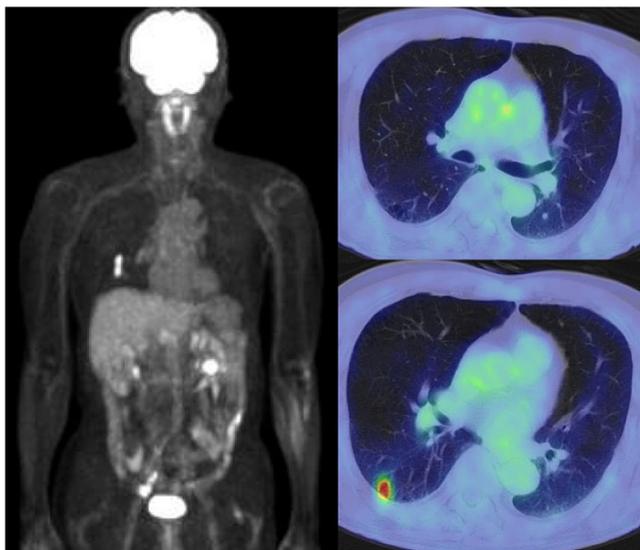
Preoperative FDG-PET demonstrated an uptake of FDG in the pulmonary tumor, but no other significant uptake was evident. FDG uptake was not observed in the mediastinal and hilar lymph nodes
